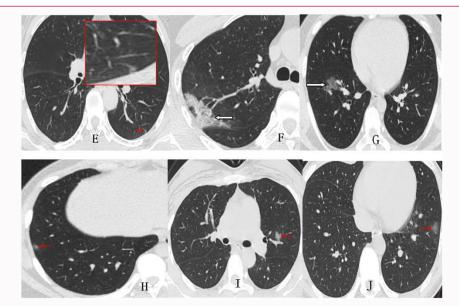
Imported cases: 50-year-old female, 2020.3.11 From Milan, Italy, *via* German transfer to Shanghai, China, fever for 1 day, CT shows subpleural Ground-Glass Opacity (GGO) with halo sign in the lower left lobe (E), subpleural Ground-Glass Opacity (GGO) in the posterior segment of the right upper lung with "crazy-paving pattern" and local vessel thickening (F); 18-year-old male, from Chicago, USA, *via* Taipei, to Shanghai, 2020.3.17, The patient was transferred from the isolation point by ambulance for cough 6 days, CT shows Ground-Glass Opacity (GGO) in the lower lobe of the right lung (G), subpleural nodule shadow with halo sign (H); 27-year-old female who came from London, UK to Shanghai, cough and fever for 1 day, from the self-isolation point transferred by the ambulance to see the doctor. The CT shows Ground-Glass Opacity (GGO) in the upper lobe of the left lung (I), the Ground-Glass Opacity (GGO) in the lower lobe of the left lung, with halo sign, and the "crazy-paving pattern" can be seen (J).
